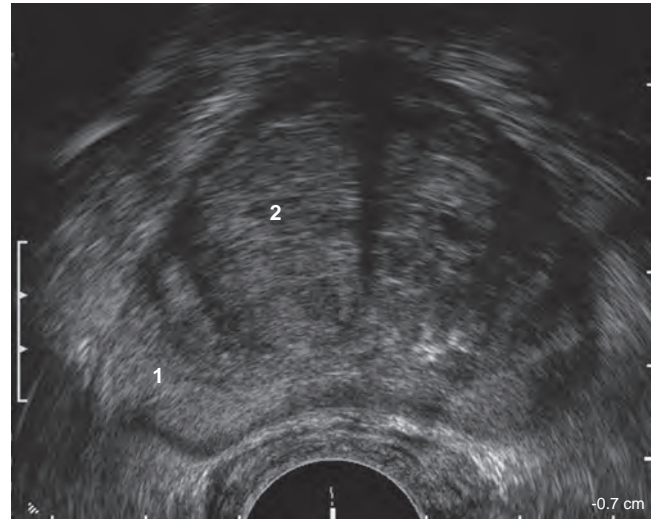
Transrectal ultrasound of the prostate demonstrating the peripheral zone (1) and the transition zone (2).
